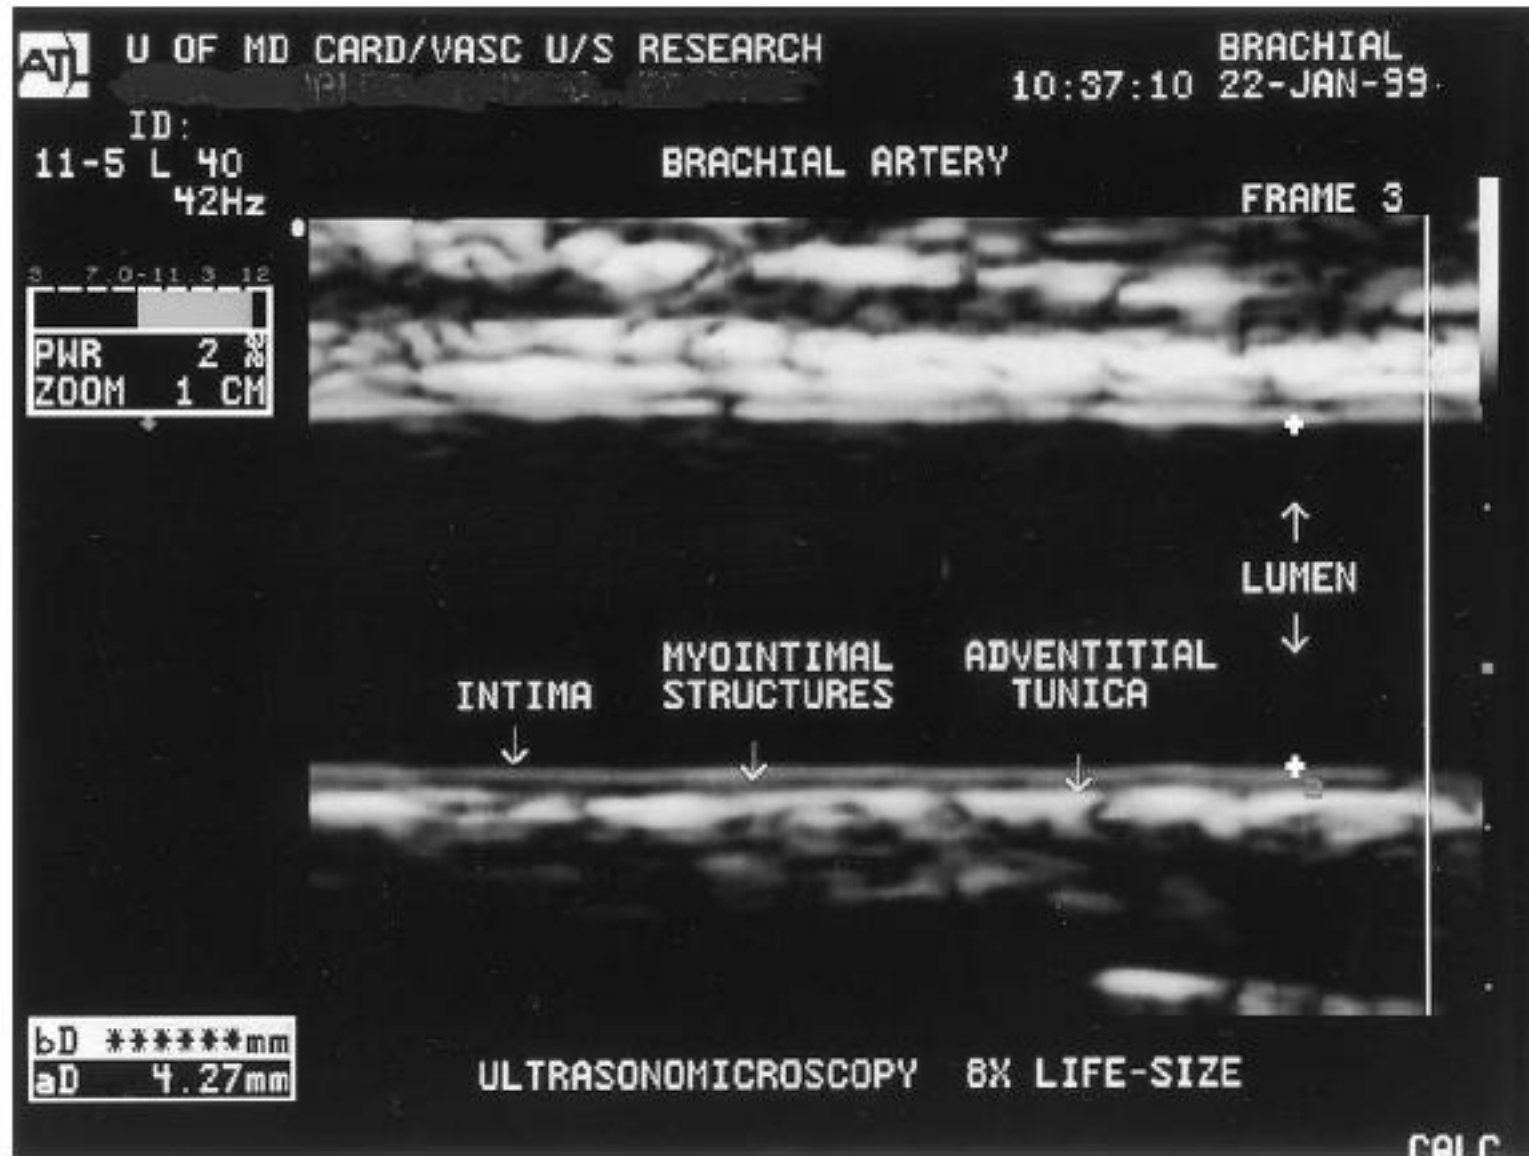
Ultrasound image of the brachial artery (longitudinally) at 8× magnification, 11-MHz transducer frequency annotated for anatomic landmarks.
